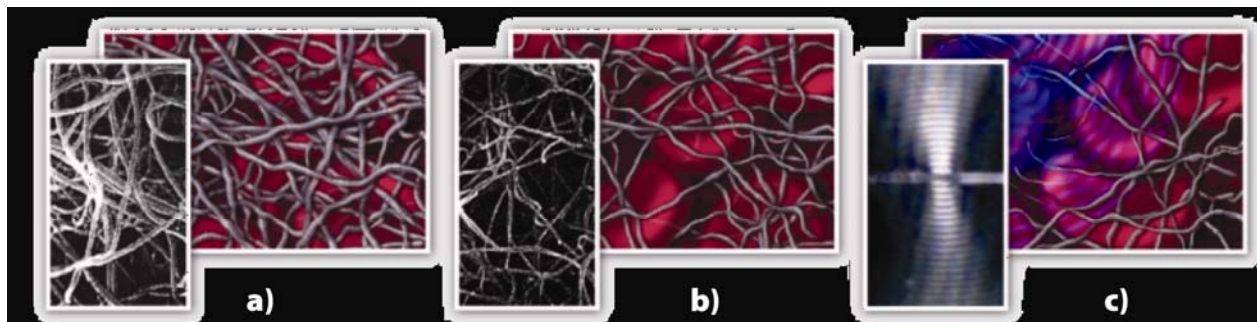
Fibrin network dissolution by: a) Only thrombolytic therapy; b) Only ultrasound; c) Ultrasound and thrombolytic therapy.
